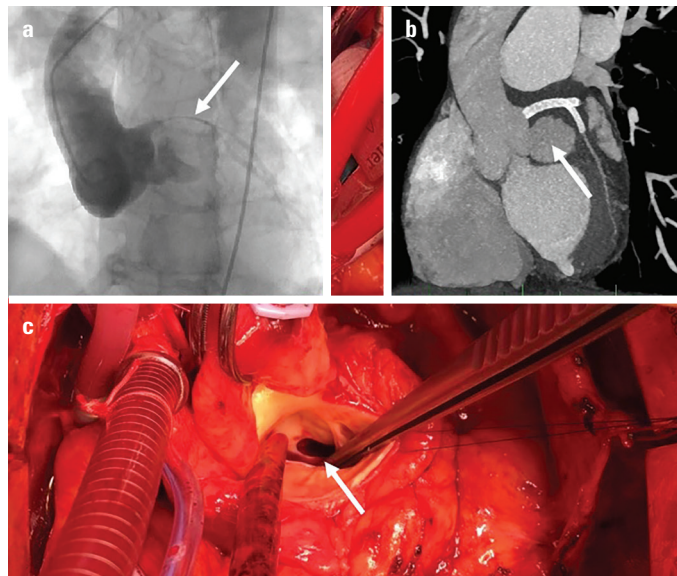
(a) (Coronarography)-pseudoaneurysm of the left coronary sinus causes significant stenosis of the left coronary artery. (b) (CT angiography)-pseudoaneurysm of the left coronary sinus, stented left coronary artery. (c) (Perioperative)-entry to the pseudoaneurysm with smooth edges
